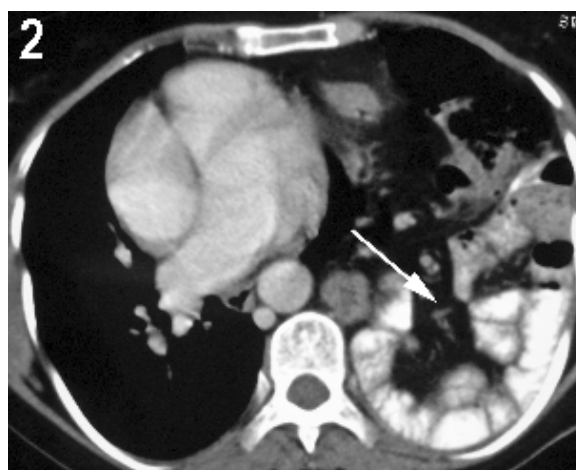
Computed tomography of the abdomen, showing herniation of intra-abdominal contents into left chest in a patient with Bochdalek hernia.
